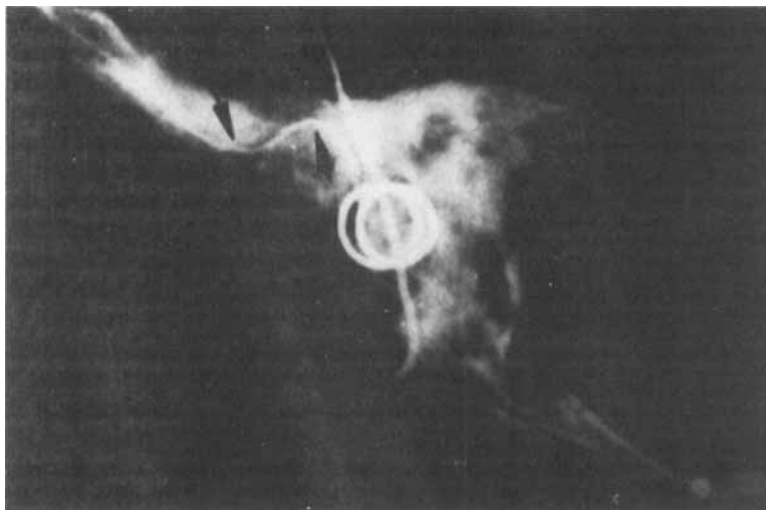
The shape of the right articular surface and the clival plane is clearly visible on a lateral roentgenogram. The left fossa, which was not measured, is visible as a darker area above the right fossa.
